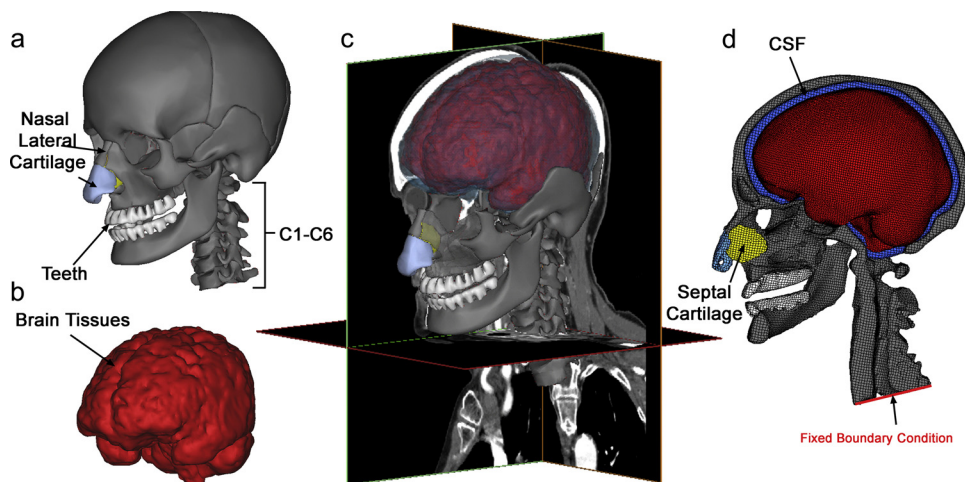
Various components of a subject-specific model of (a) human skull and (b) brain segmented from (c) CT and MRI data by Mimics. (d) The meshed model on the right shows the mid-sagittal view of the skull and CSF except the brain.
